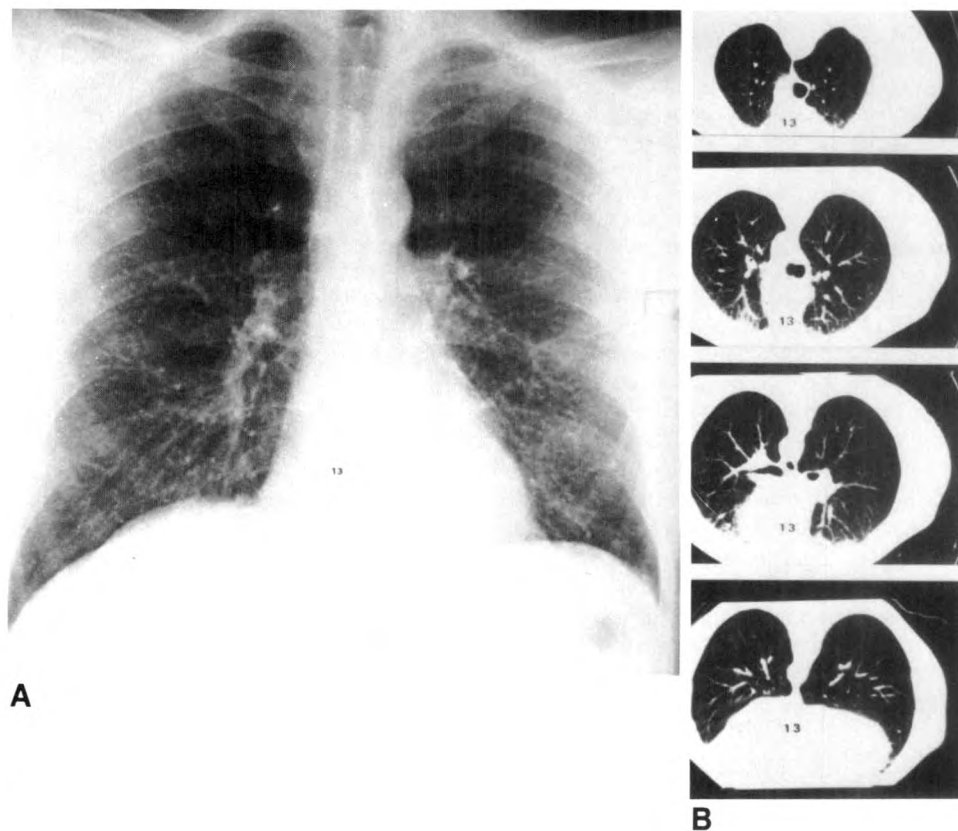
Chest radiograph (A) and CT scans (B) of patient with simple silicosis. Opacities are evident on plain radiograph but are not seen on CT scan.
